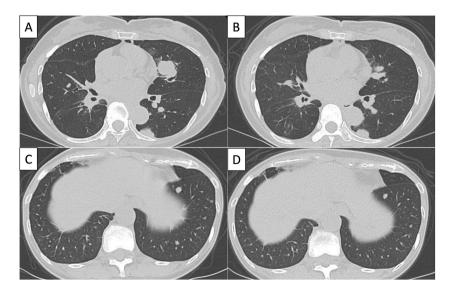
Computed tomography of the chest confirms shrinkage of the primary and metastatic site of the lung cancer and revealed no evidence of diffuse ground-glass opacities after the rechallenge of osimertinib (A–D).
